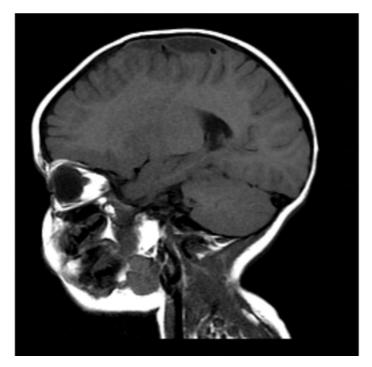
T1-weighted MRI in sagittal view demonstrates extra-axial collection located in the high convexity of the frontopariental region on the right, with content showign a slightly increased signal in relation to the CSF
